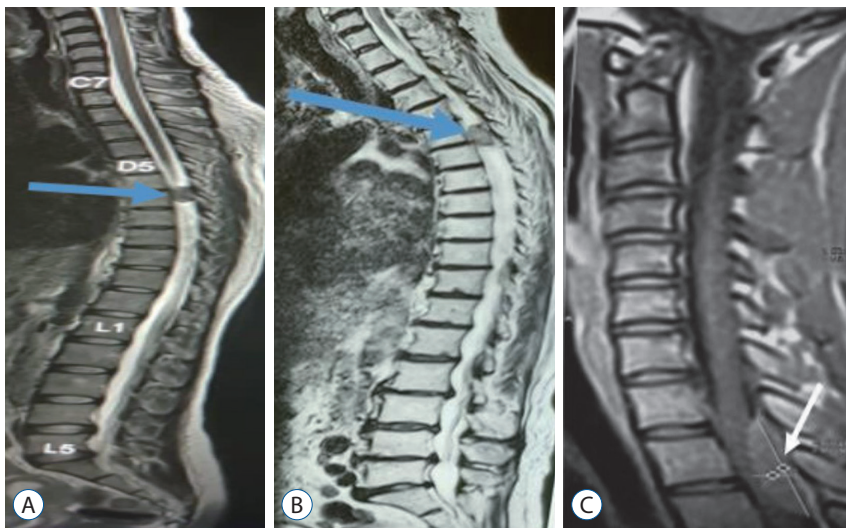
Preoperative sagittal magnetic resonance images of case 1 (A), 2 (B) and 3 (C). T2 weighted image shows an intradural and extramedullary meningioma (blue arrow in A, B; white arrow in C).
